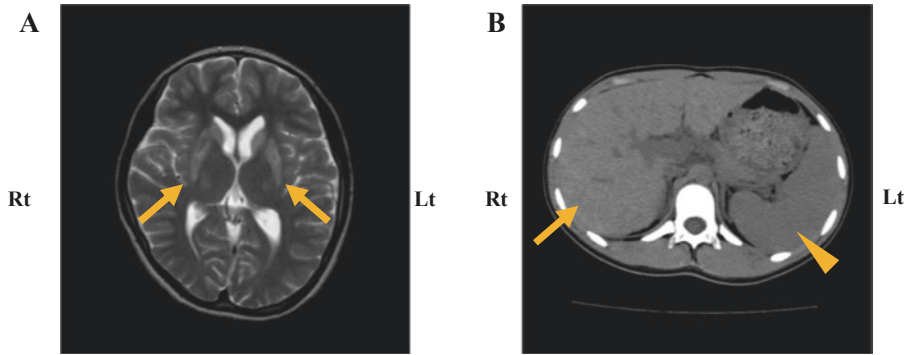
Brain MRI and abdominal CT scan in Case 2. (a) T2-weighted image of brain MRI. Arrows indicate high intensity regions in the basal ganglia. (b) Abdominal CT scan. It shows irregularities of the external contour and heterogeneous density of the liver (arrow) and splenomegaly (arrowhead)
